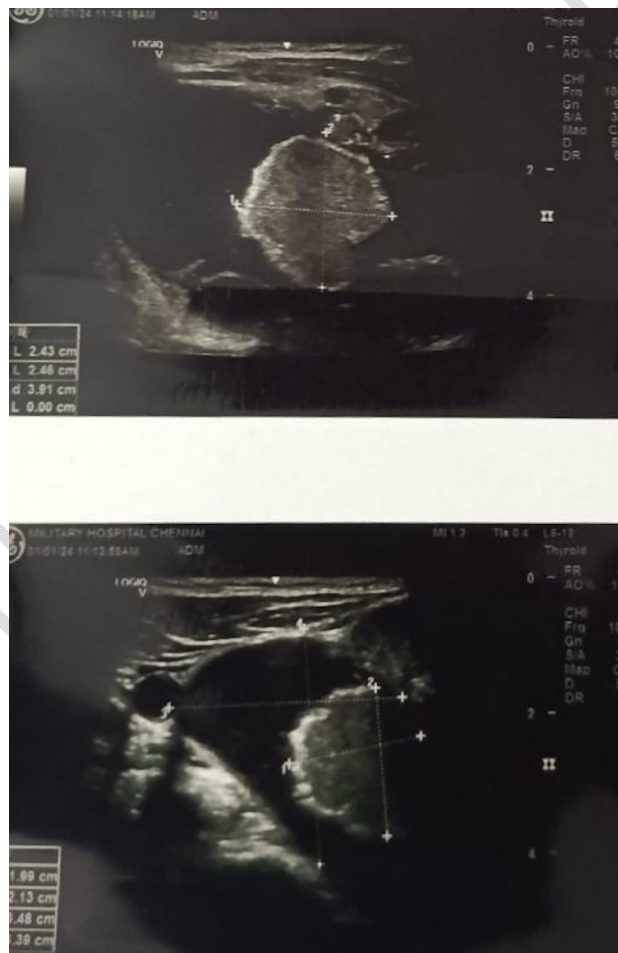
Ultrasonography of the right lobe thyroid showing a solid and cystic
